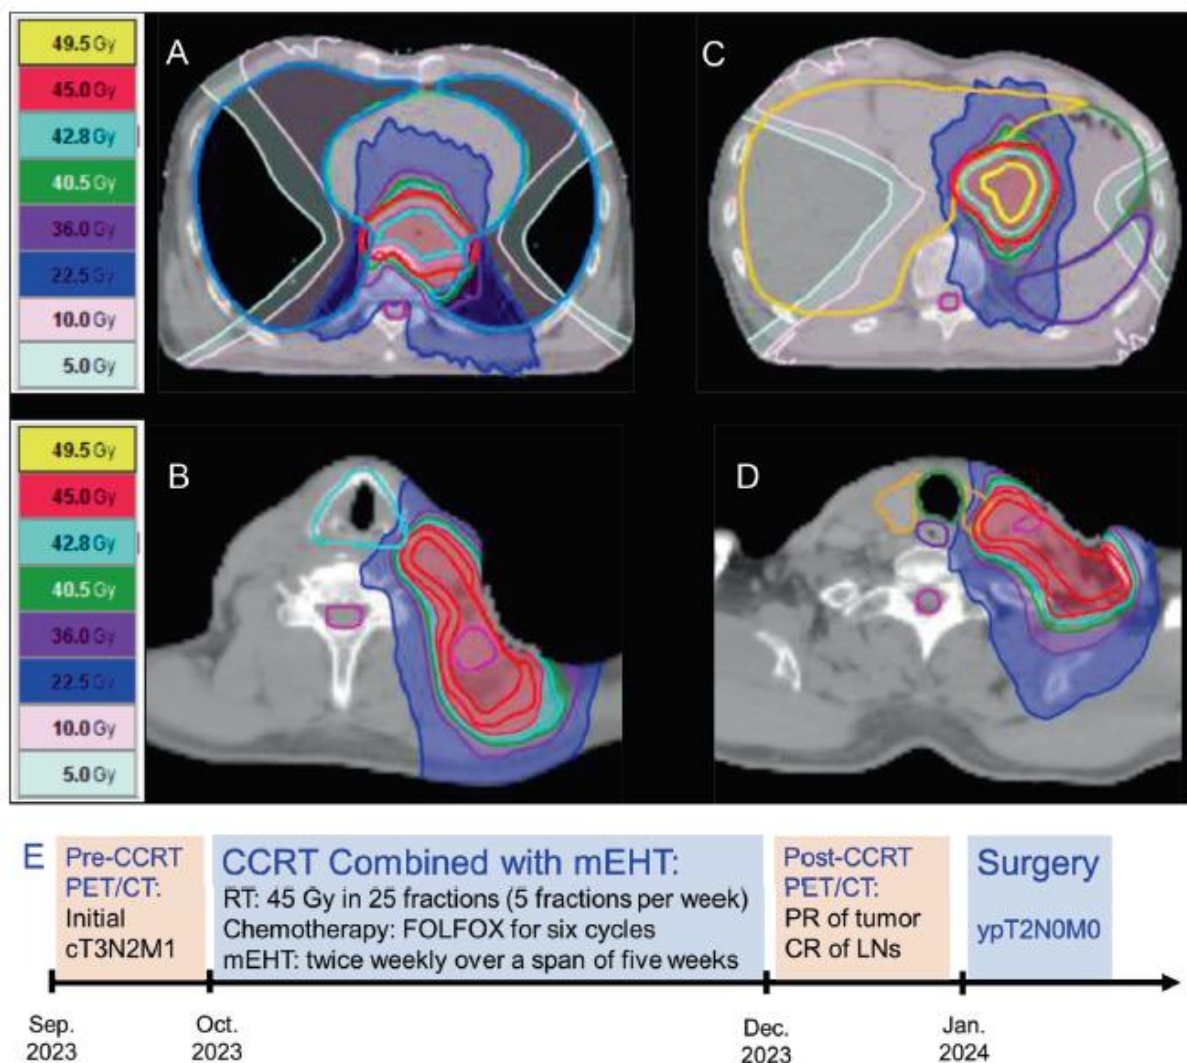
Radiation dose distribution from the radiotherapy treatment plan and an overview of the clinical course for a 60-year-old male diagnosed with lower esophageal squamous cell carcinoma, cT3N2M1, stage IVB. The planning target volume (PTV) of 45 Gy (red area) is focused on the primary esophageal tumor in the lower third of the esophagus (A), the left neck level V nodal metastasis (B), the celiac nodal metastasis (C), and the left supraclavicular fossa nodal metastasis (D). This distribution targets both the primary tumor and regional as well as distant metastatic lymph nodes identified on PET/CT and CT imaging. (E) an overview of the patient's clinical course. CCRT: Concurrent chemoradiotherapy. mEHT: Modulated electro-hyperthermia. PET/CT: Positron Emission Tomography/Computed Tomography. PR: Partial response. CR: Complete response.
